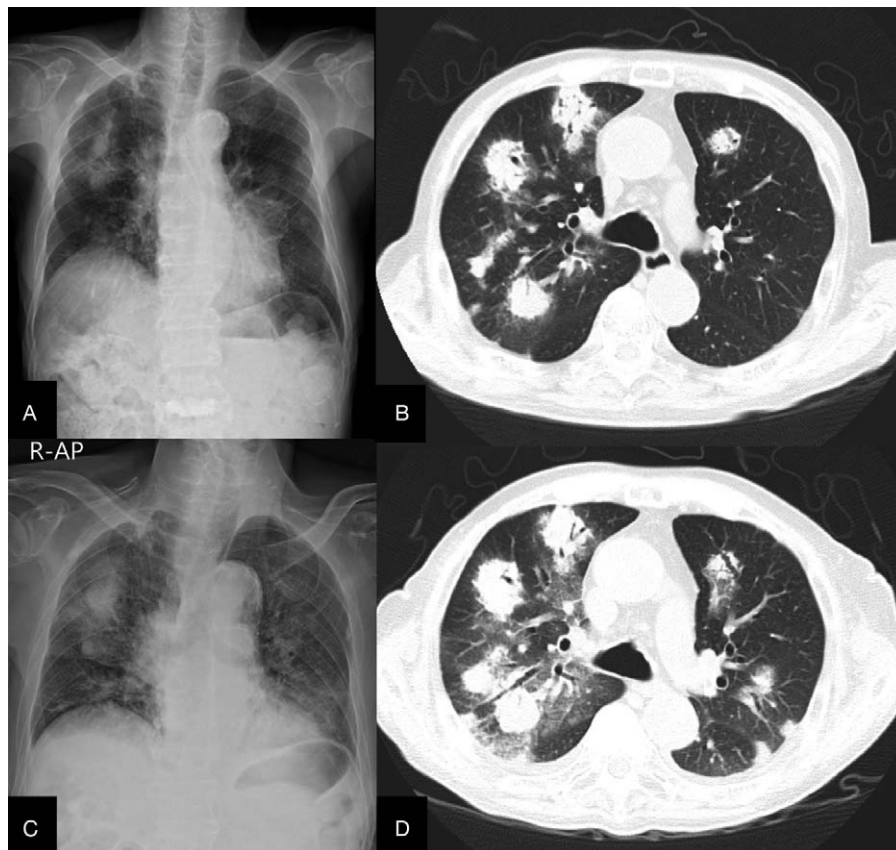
(A) Initial chest radiograph showing multiple nodular lesions in both lung fields. (B) Chest computed tomography (CT) scans revealing multifocal consolidations with ground-glass opacity and right pleural effusion. (C and D) Follow-up chest radiograph and chest CT scans demonstrating interval aggravation of multiple nodular opacities.
